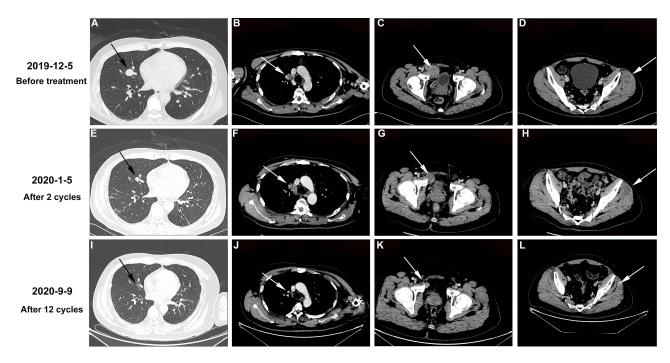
Computerized tomography (CT) was performed before and after sintilimab plus anlotinib therapy. (A-D) CT scan of the mass in the right lung, the mediastinal lymph nodes, the mass in the right pubic and the mass in the subcutaneously left iliac region before the treatment, respectively (arrow); (E-H) CT scan of the mass in the right lung, the mediastinal lymph nodes, the mass in the right pubic and the mass in the subcutaneously left iliac region after 2 cycles of sintilimab plus anlotinib therapy, respectively (arrow); (I-L) CT scan of the mass in the right lung, the mediastinal lymph nodes, the mass in the right pubic and the mass in the subcutaneously left iliac region after 12 cycles of sintilimab plus anlotinib therapy, respectively (arrow).
